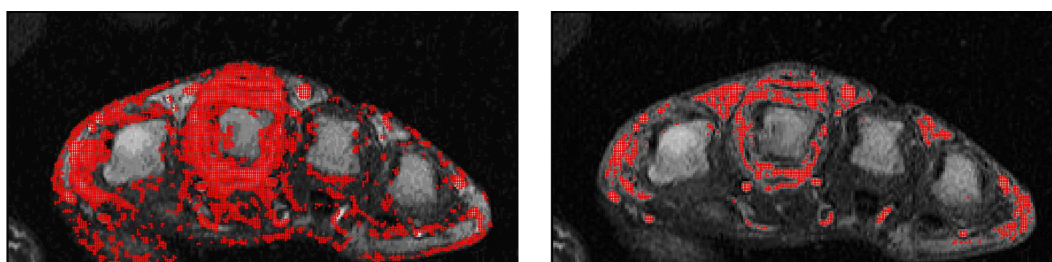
Left: A post-contrast image from a sample DCE-MRI slice with enhancing pixels shown in red. Right: The same image after classification with PCA: pixels classified as vessels are shown in red.
